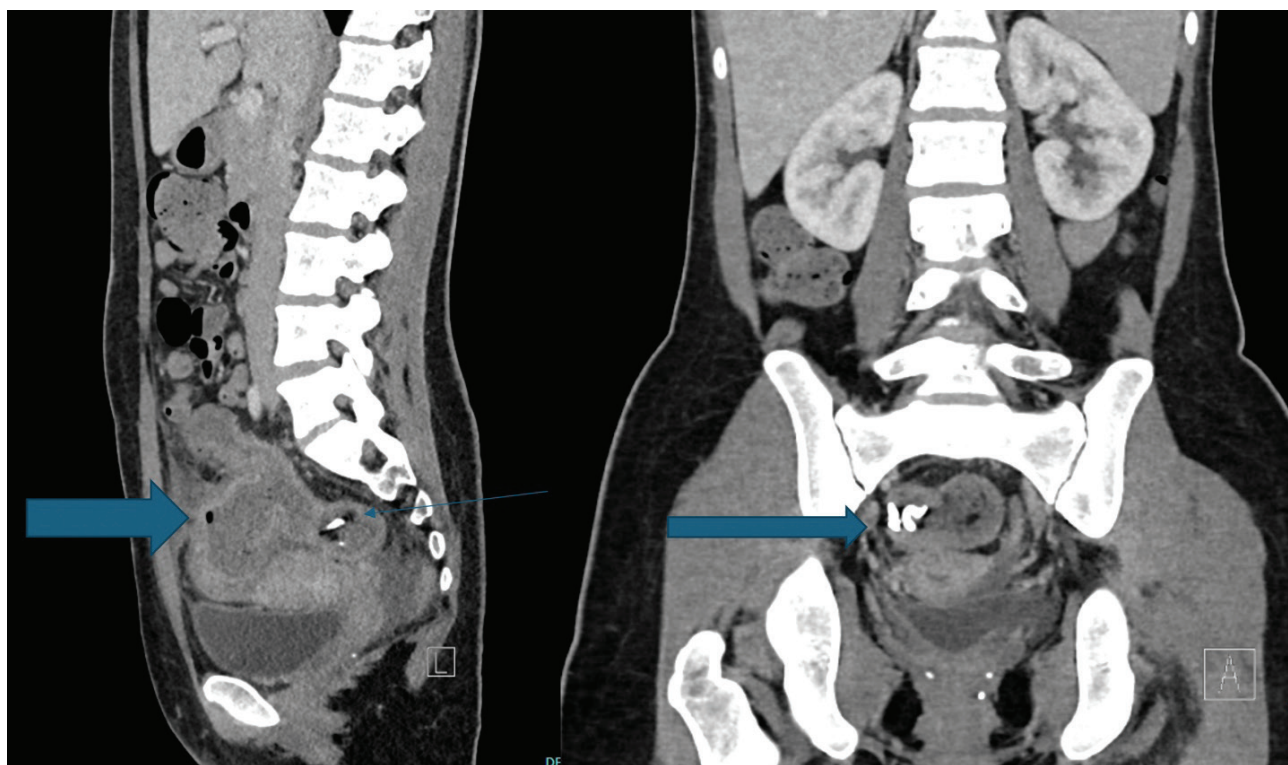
CT-scan – Dermoid within the sigmoid colon. Sagittal View: Small Blue Arrow demonstrates Dermoid in Rectum; Large Blue Arrow shows fistula in sigmoid colon. Coronal View: Large Blue arrow highlights the Dermoid cyst.
